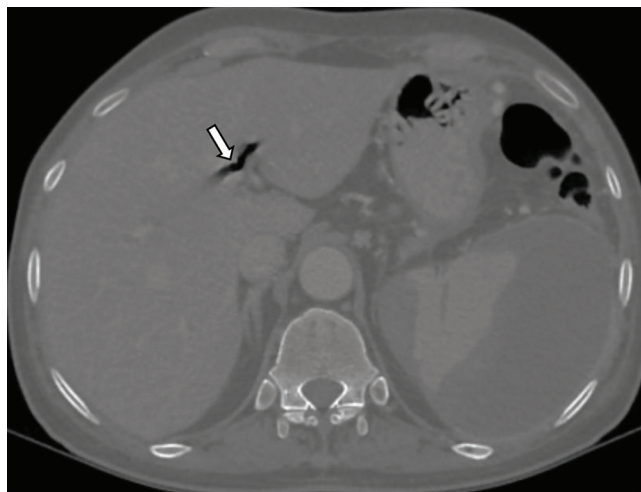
Axial CT section shows Pneumobilia (arrow)
